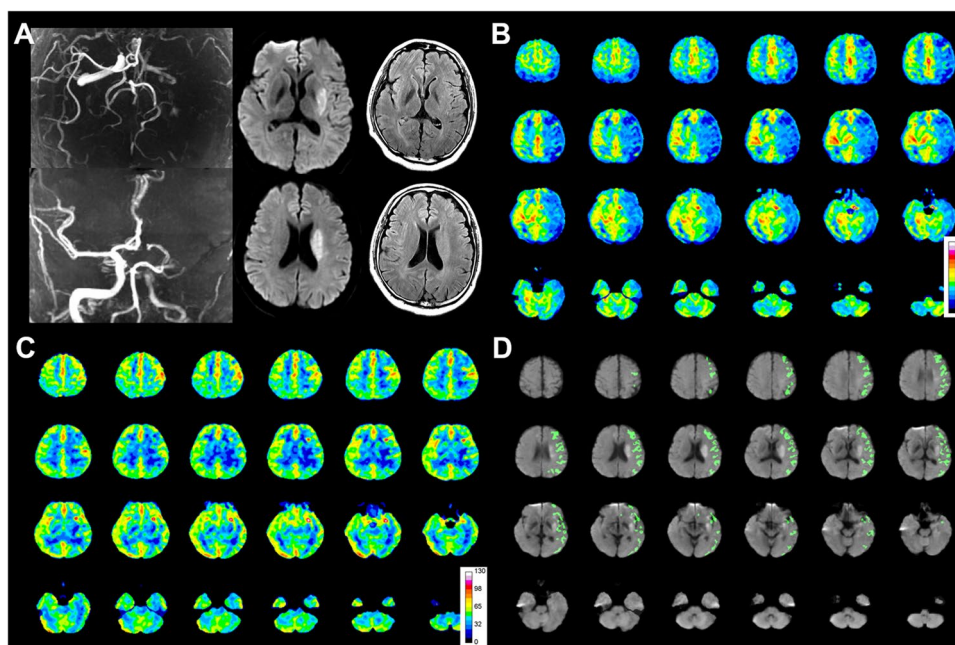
Representative case exhibiting a high collateral-core ratio and a better clinical outcome. Figure shows a 40-year-old male patient with acute left distal internal carotid and middle cerebral artery occlusion. Diffusion-weighted imaging (DWI) demonstrates a basal ganglia region infarction with a volume of 12.65 mL (A). Territorial hypoperfusion can be observed on cerebral blood flow maps on
